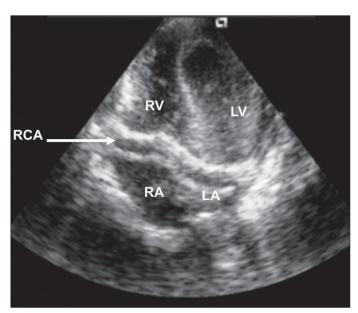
Apical four-chamber echocardiographic image: dilated right coronary artery (arrow)
